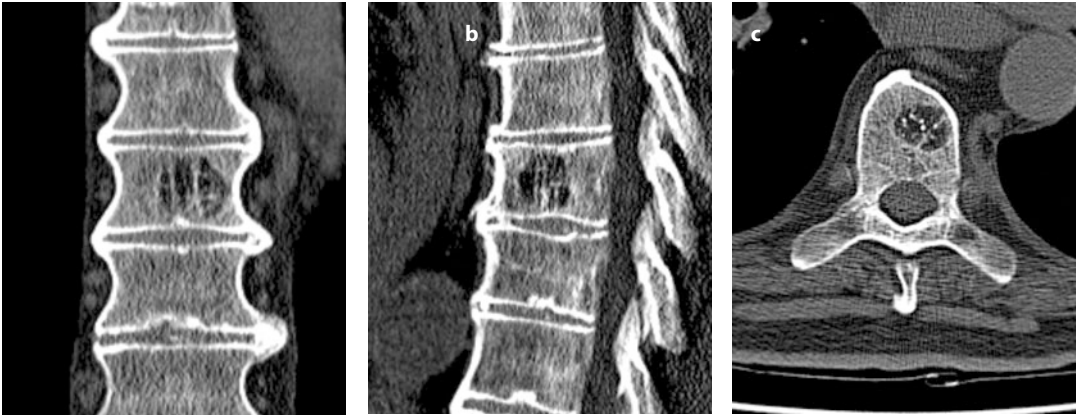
Coronal (a), sagittal (b) and axial (c) CT with bone algorithms of a single vertebral body hemangioma in the thoracic spine. Multiple dots (“polka dots”) representing a cross-section of reinforced trabeculae in the center of the vertebral body are seen
